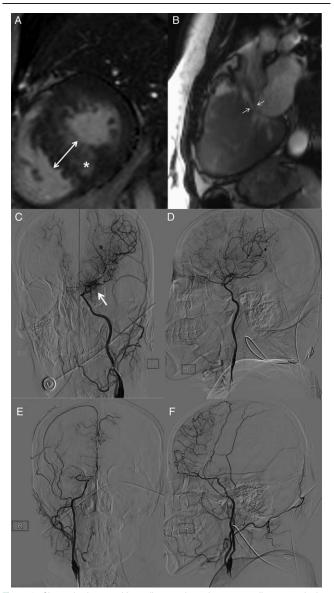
Obstructive hypertrophic cardiomyopathy and moyamoya disease coexist in a patient. Asymmetric hypertrophy involving the interventricular septum with a maximum thickness of 32 mm (A; double-headed arrow) and focal late gadolinium enhancement (A; asterisk), as well the left ventricular outflow obstruction at mid-systole (B; between thin arrows) by cardiac magnetic resonance imaging; and steno-occlusion of the distal left (C and D) and right (E and F) internal carotid arteries and typical moyamoya collaterals in the basal region of the left brain hemisphere (C; thick arrow) by transcatheter angiography.
